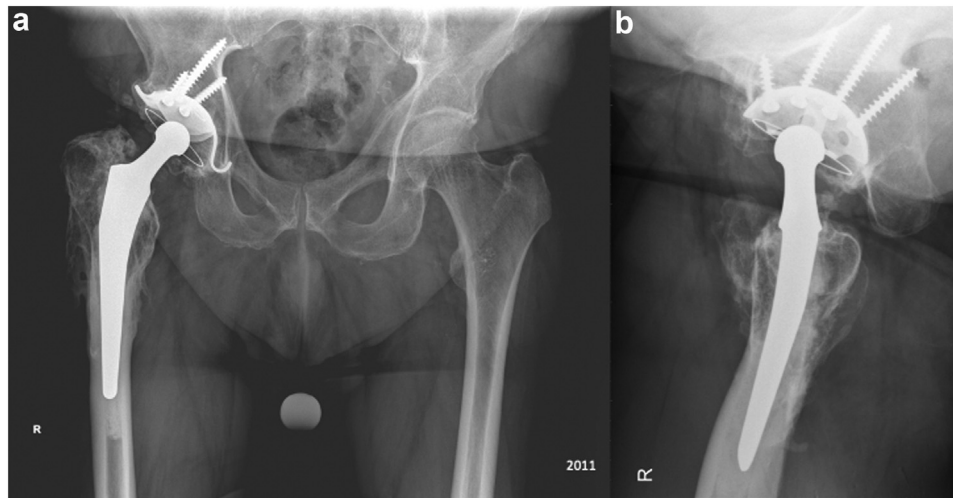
Anteroposterior (a) and lateral (b) radiographs demonstrating well-fixed components. A mature heterotopic bone evident on the AP and lateral view. No loosening visible of either component.
